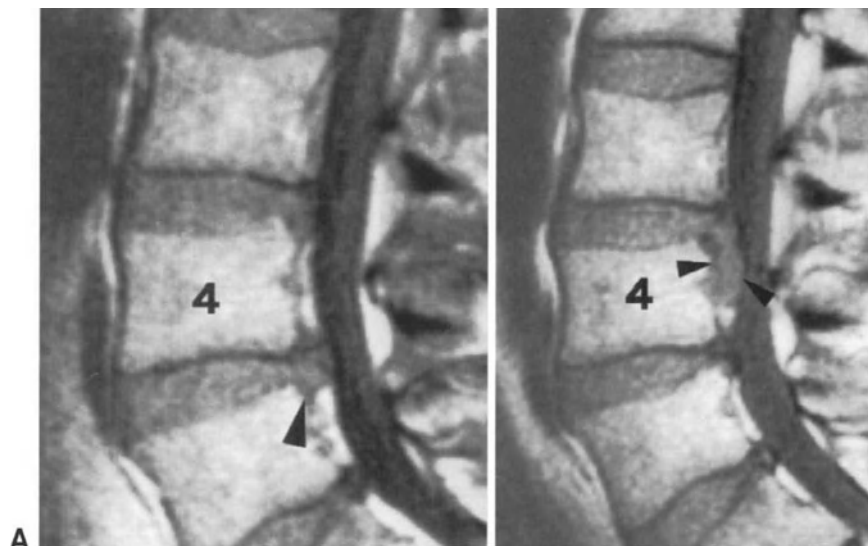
MRI scans of a patient with disc herniation at a new level. (A) Spin-echo T1-weighted sagittal image obtained before primary discectomy, showing disc herniation at L4-L5 level (arrowhead). (B) Spin-echo T1-weighted sagittal image 3 years after discectomy, revealing a disc fragment migrated caudally to the L3-L4 disc (arrowheads).
